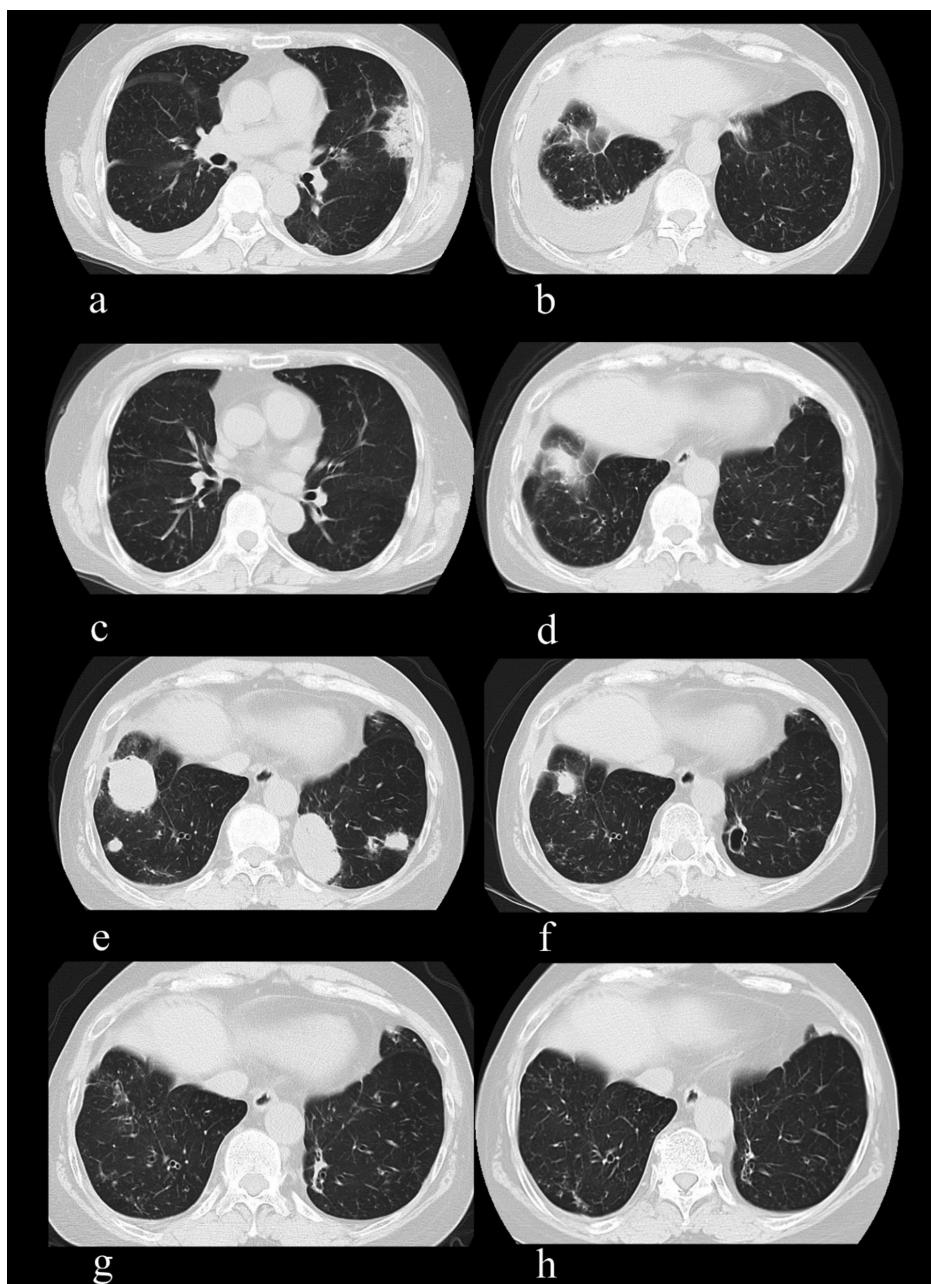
Changes in chest CT images of Patient 2. (a) Axial image at the level of the arrowhead in Figure 3b. Right lung pleural effusion and left lung showing shadow. (b) Axial image at the level of the arrow in Figure 3b. Marked pleural effusion in the right lung. (c) Pleural effusion seen in (a), and (d) shadow seen in (b) have disappeared 9 months after high-dose steroid treatment. (e) Multiple nodules in both lungs at the time of the diagnosis of LPD. (f) The nodular shadows in both lungs were markedly reduced 5 months after discontinuation of MTX. The large para-aortic nodule in the left lung formed a cavity. (g) The nodular shadows had almost disappeared 11 months later. (h) LPD has not recurred during 51 months of follow-up.
